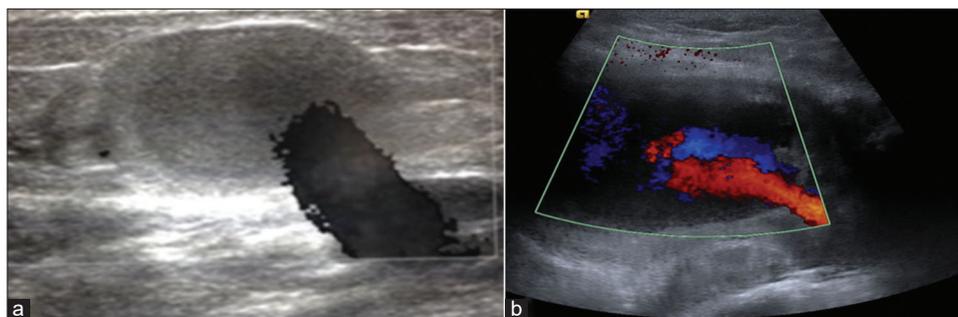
Transverse ultrasound image (a) of the popliteal artery demonstrating a jet of blood flowing into a thrombosed pseudoaneurysm secondary to trauma. (b) Ultrasound demonstrating the turbulent forward and backward flow where a characteristic Ying-Yang sign may be seen on color flow Doppler.
